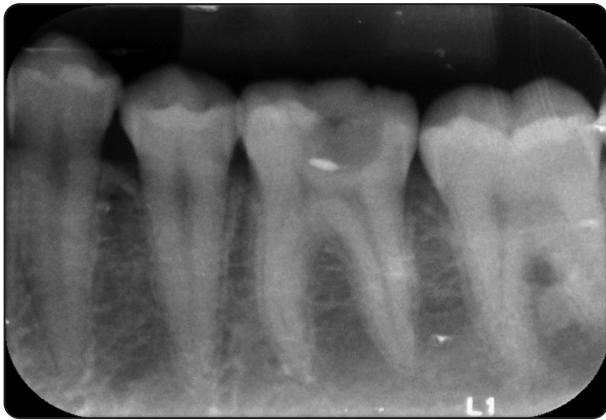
Baseline Digital radiograph (T0) deep caries lesion before Fuji XI application
